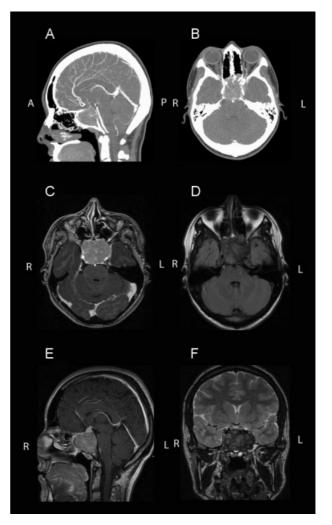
Computed tomography angiogram scans with bone window sagittal (A) and axial (B) showing large central skull base lesion with mass effect over the internal carotid arteries and basilar artery. There is erosion of the floor of the sella turcica with extension into the sphenoid sinus. The mass caused cranial displacement of the pituitary stalk. (C) Axial enhanced magnetic resonance imaging disclosing invasive expansile mass in the central skull base with signal intensity most consistent with partial osteoid matrix. (D–F) Magnetic resonance imaging axial (D), sagittal (E), and coronal (F) disclosing large central skull base mass with mass effect on internal carotid arteries and encasing the left carotid artery.
